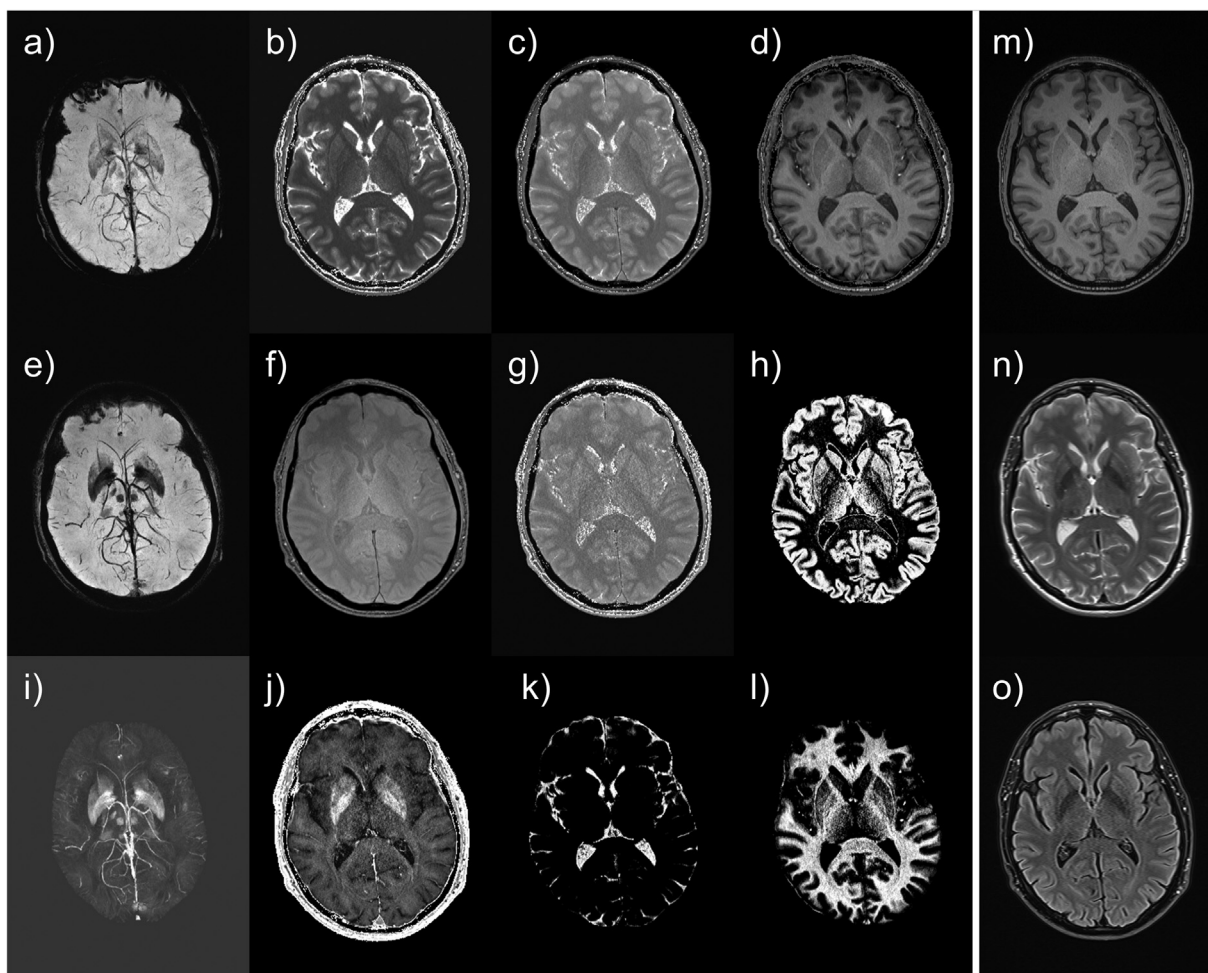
Comparison between STAGE and conventional MRI on a 67-year old male healthy control subject scanned with the double-echo version of STAGE on a 3 T scanner. Images in the left panel (a-l) were from STAGE taking 5 min with a spatial resolution of $0.67 \times 1.34 \times 2.0 \text{ mm}^3$ and 64 slices covering the whole brain. Images in the right panel (m-o) were from conventional MRI providing only T1, T2 and FLAIR in 5.5 min with the same resolution and coverage. a) SWI; b) T1 map; c) PSD map; d) T1WE; e) tSWI; f) PDW; g) tPSD map; h) sDIR-GM; i) QSM; j) $R2^*$ map; k) sDIR-CSF; l) sDIR-WM; m) T1-MPRAGE; n) T2 TSE; o) T2 FLAIR. The images for SWI, tSWI and QSM were minimum/maximum intensity projections with an effective slice thickness of 16 mm.
